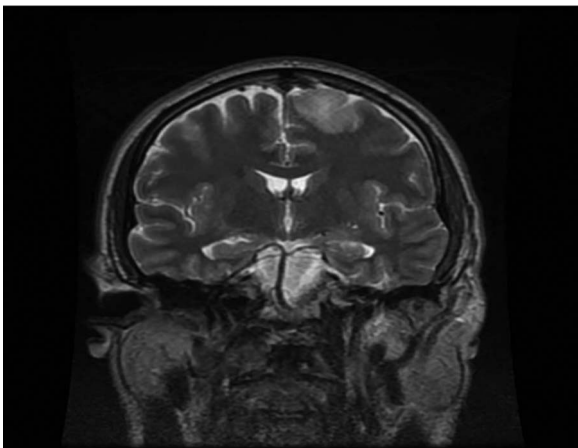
Coronal T2-weighted image showing blurring of superior sagittal sinus flow.
